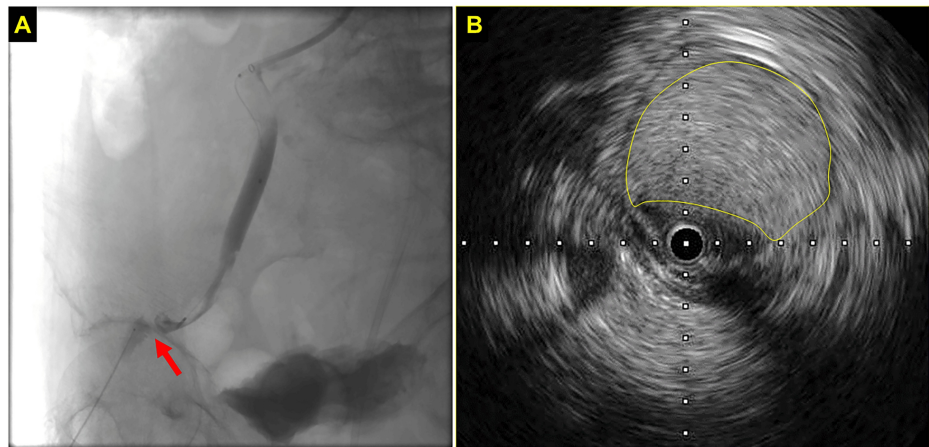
Endovascular therapy during TAVI (A) and the finding of intravascular ultrasound (B)
